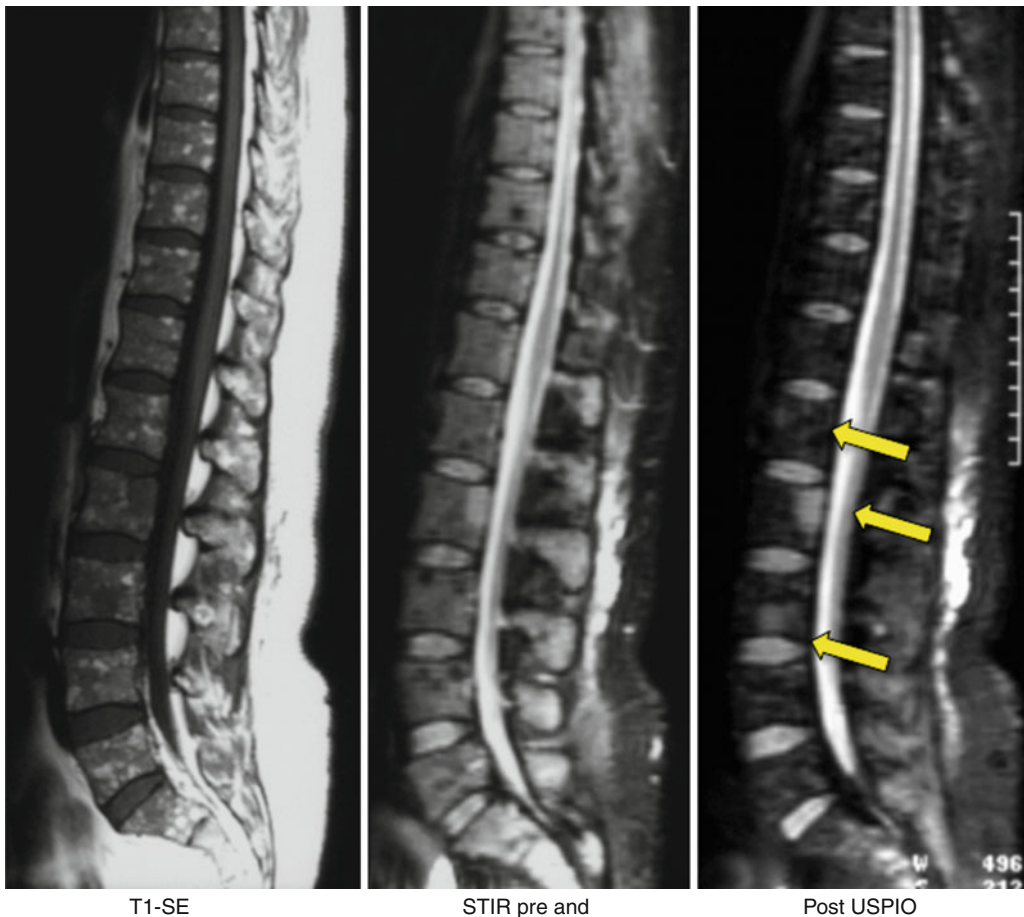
Sagittal MR images of the spine of a patient with malignant lymphoma and multifocal bone marrow infiltration, status post chemotherapy and GCSF treatment. The reconverted, highly cellular hematopoietic marrow demonstrates low signal on plain T1-weighted MR images and high signal on STIR images, masking T1-hypointense and T2-hyperintense focal bone marrow
